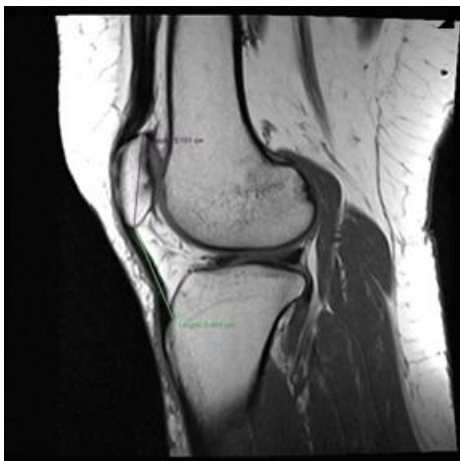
Patellar height ratio measured on sagittal T1 - weighted turbo spin - echo MR images as B/A
